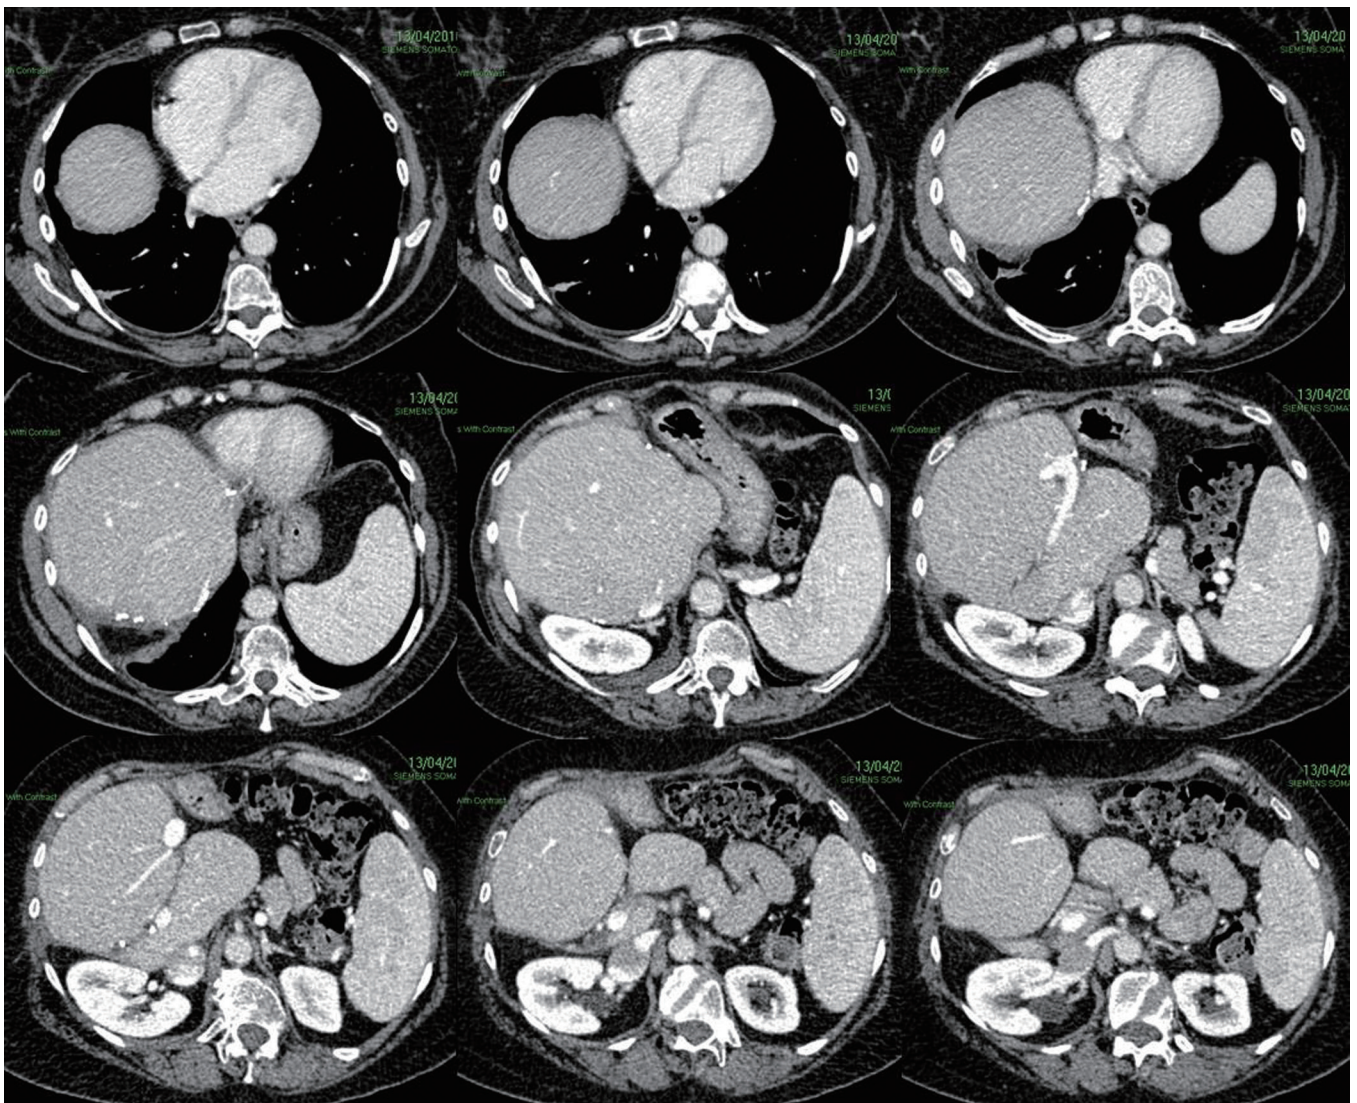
Patient 1 follow up triple phase CT with no evidence of recurrence.
